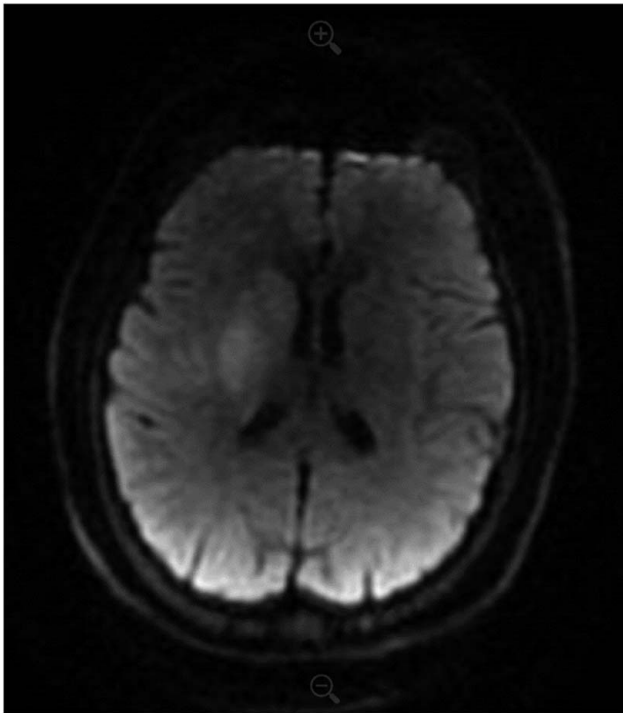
MRI of brain, reveals acute infarction in the right basal ganglia, confirmed by abnormal restricted diffusion and T2 FLAIR hyperintensity, suggestive of a significant ischaemic event.
